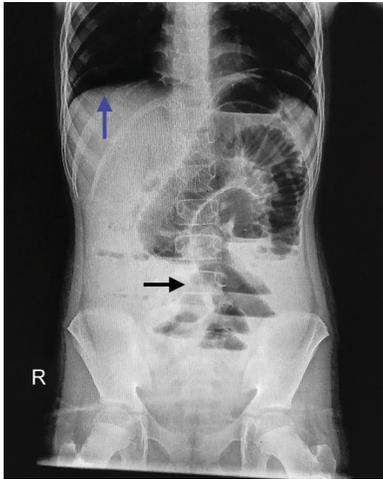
Abdomen X-ray showing free air under the diaphragm (blue arrow) with multiple air-fluid levels (black arrow) on POD 13
